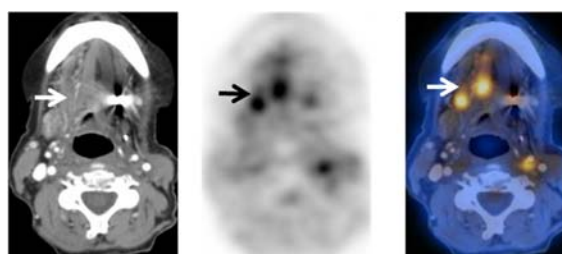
A79-year-old female with a history of tongue cancer status post left hemiglossectomy, left partial pharyngectomy and left neck dissection followed by radiation therapy. CT scan, PET scan and fused PET/CT scan shows focally increased uptake at the tongue muscle (arrow) without any discrete mass on the accompanying contrast enhanced CT scan. These findings are interpreted as physiologic uptake
